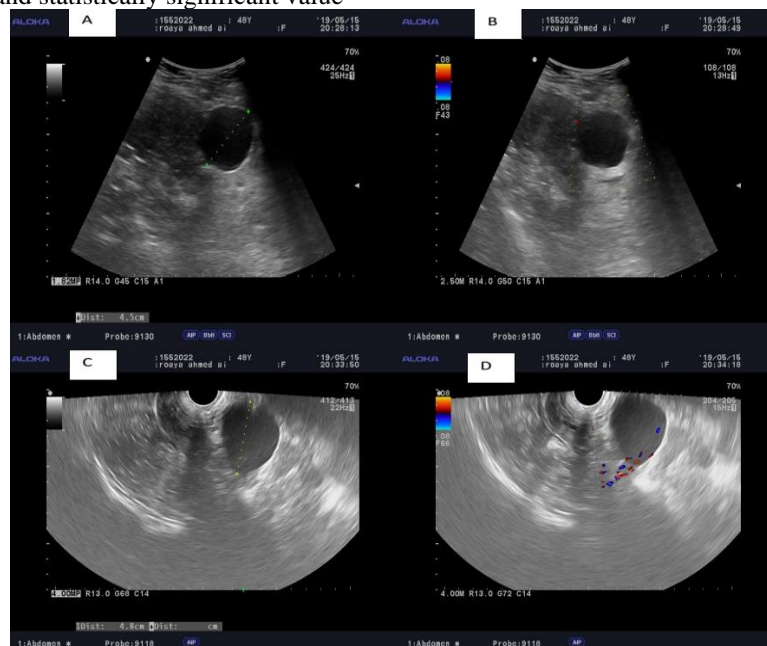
48 years old patient with history of operated breast cancer on regular follow up presented with abdominal pain and distension (1) Trans-abdominal (a&b) and trans vaginal (c&d) was done showing left ovarian cystic lesion anechoic in nature measures +/- 4.5 cm in maximum dimensions with no vascularity on color mapping (CS:1), (2) Follow up was done after 10 weeks showing the same left ovarian anechoic cyst with no vascularity on color Doppler. Diagnosis: Left ovarian simple cyst O-RADS 2
